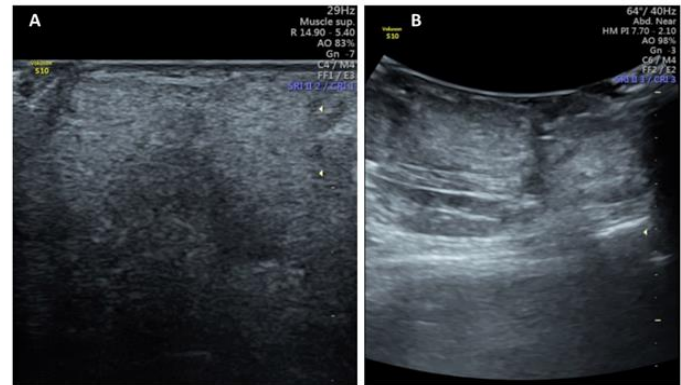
USG of the swelling. (A) High-frequency linear probe image showing a well-defined, homogeneously hyperechoic lesion in the hypothenar region, consistent with a lipomatous mass. (B) Convex probe image depicting the overall contour and boundaries of the lesion. USG - Ultrasonogram.
